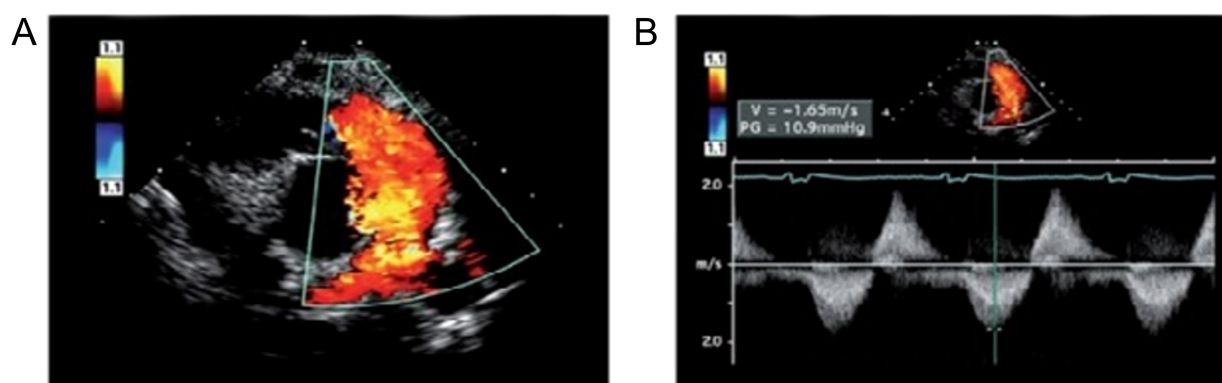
Echocardiography of severe pulmonary regurgitation in a patient after repair of tetralogy of Fallot. (From Vyas HV, Johnson JA, and Eidem BW. Tetralogy of Fallot. In [13]; used with permission of Mayo Foundation for Medical Education and Research.) (A) Color Doppler image showing a broad jet of regurgitant flow extending into the branch pulmonary arteries and suggesting severe pulmonary valve regurgitation. (B) Continuous-wave Doppler image showing a dense signal (pulmonary regurgitation) during diastole with a rapid return of the signal to the Doppler baseline, consistent with equalization of the right ventricular and pulmonary arterial pressures. Low V (1.6 m/s) suggests no significant residual right ventricular outflow tract obstruction. PG, peak gradient; V, systolic velocity.
